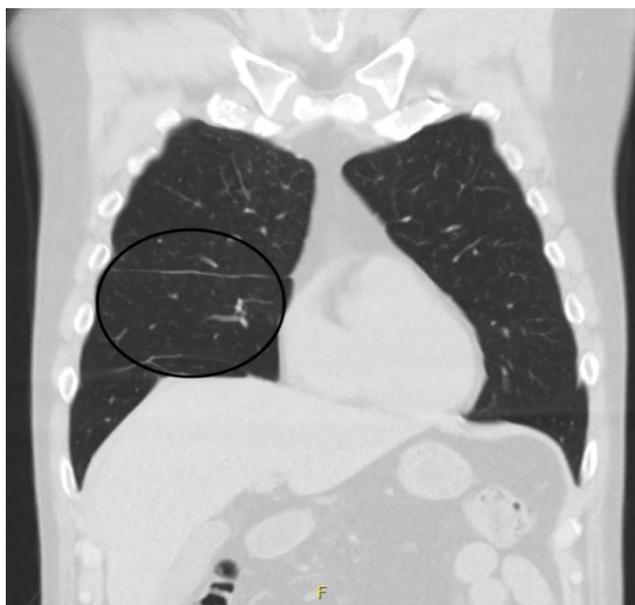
Follow-up chest computed tomography, Coronal view. Previous right middle lobe cavitory lung lesion is now resolved. Circle indicates where previous lesion was
